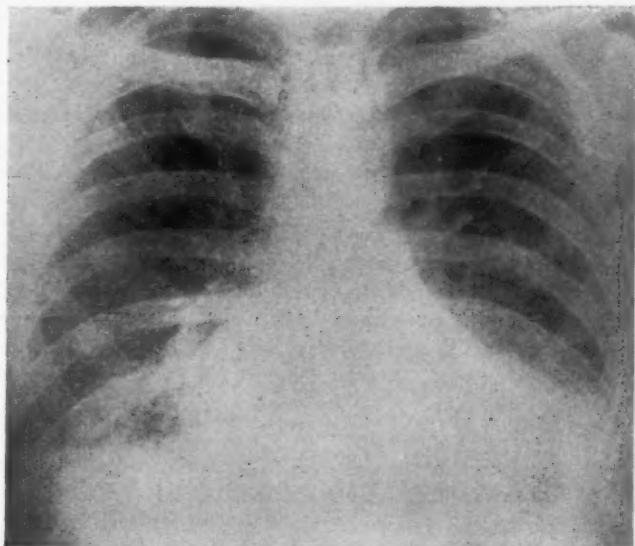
Chest roentgenogram taken four days after second hospital admission shows increased obliteration of the left costophrenic angle.
